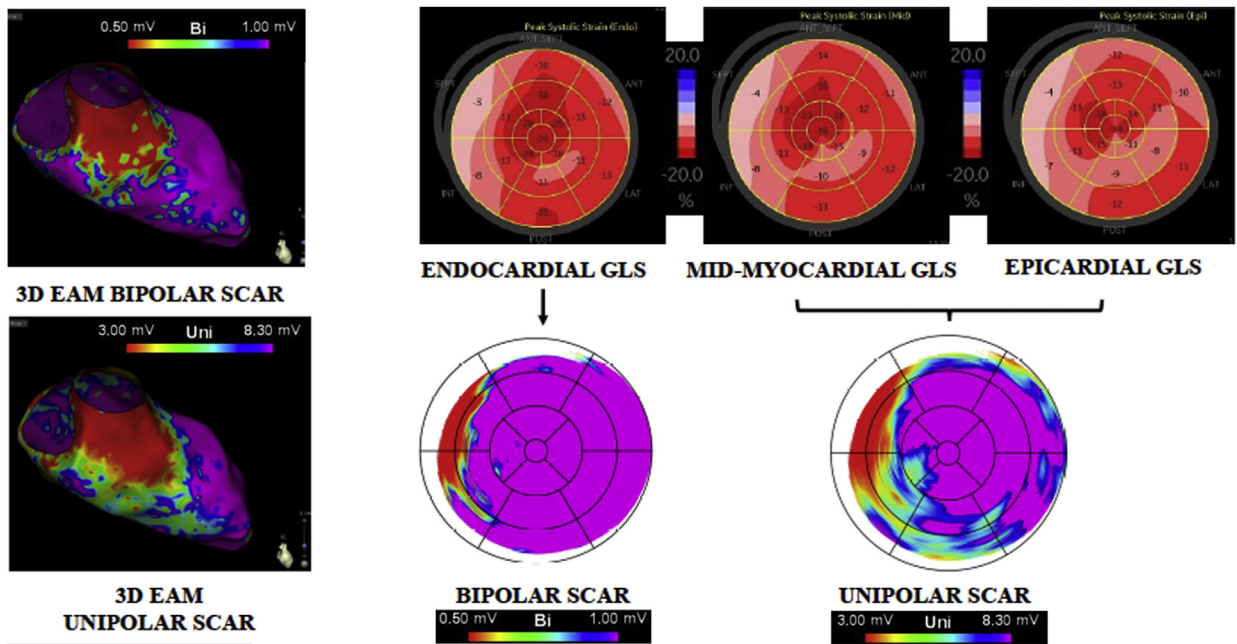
Example of a patient with nonischemic cardiomyopathy (NICM) and anteroapical scar with layer-specific speckle-tracking echocardiography (STE) parameters and bipolar and unipolar scar burden on electroanatomic mapping (EAM). STE and EAM in a 65-year-old man with NICM and ventricular tachycardia from an anteroapical scar. Left upper panel: Three-dimensional (3D) EAM demonstrating bipolar scar. Left lower panel: 3D EAM demonstrating unipolar scar. Right upper panel: Regional endocardial longitudinal strain demonstrating impaired strain in anterior and anteroapical segments (left), midmyocardial global longitudinal strain (GLS; middle), and epicardial GLS (right). Right lower panel: Bipolar scar on EAM demonstrating anterior and anteroapical scar (left), and unipolar scar on EAM (right) demonstrating a larger region of midmyocardial involvement. Low-voltage bipolar areas (<0.5 mV) are in red, healthy bipolar areas (>1.5 mV) are in purple, and colors in between are border zone (0.5–1.5 mV). Low-voltage unipolar areas (<3 mV) are in red, healthy unipolar areas (>8.3 mV) are in purple, and colors in between are border zone (3–8.3 mV).
